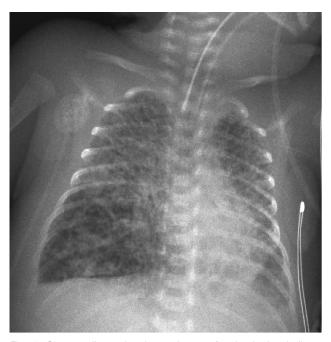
Chest radiograph taken 5 hours after instituting heliumoxygen mixture (heliox) shows decreased right-lung air-trapping and expansion of the left lung. The endotracheal tube appears higher but had not been adjusted.
